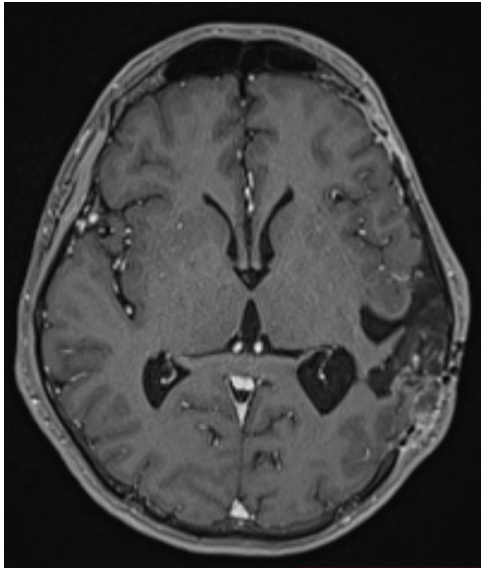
Post-operative magnetic resonance imaging (MRI) brain after the patient's second surgery
